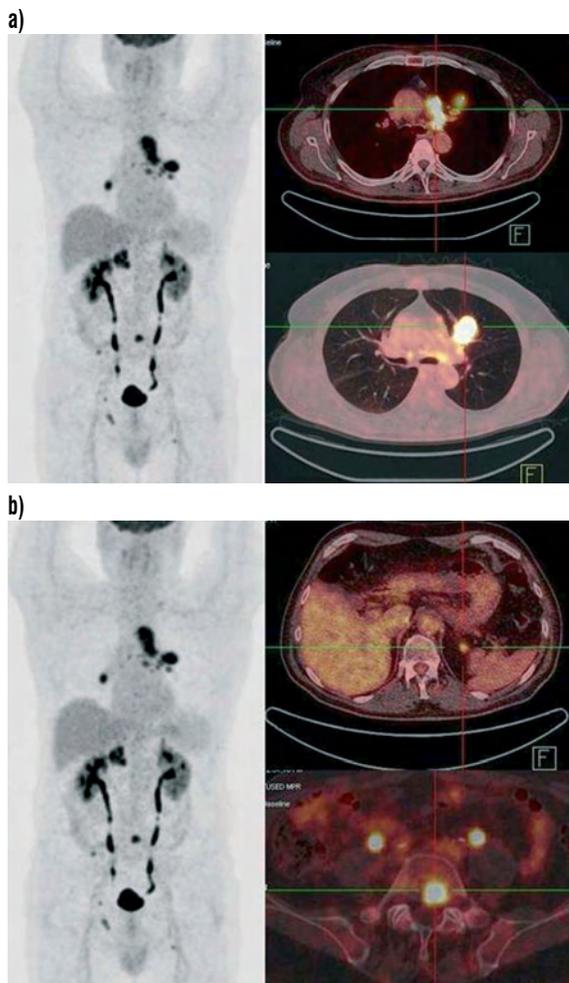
Increased F-18-FDG uptake (SUVmax 18.5) in the primary small cell lung cancer in the left lung (SCLC), with increased accumulation of F-18-FDG in mediastinal lymph nodes, contralateral hilar lymph node, left suprarenal gland and bones- extensive disease, Stage 4.
